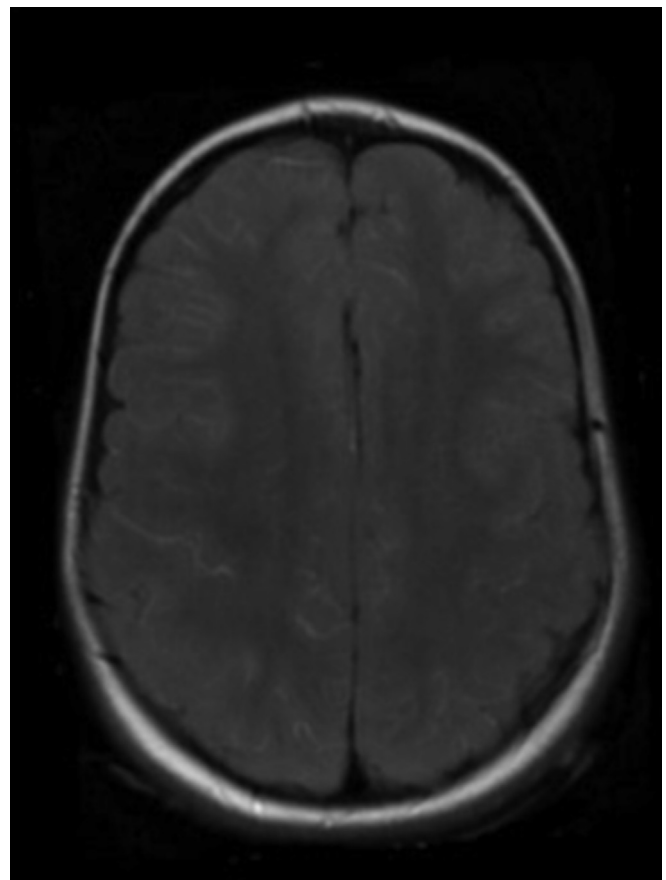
Axial T2/FLAIR image of a 16-year-old male patient with SCD, showing diffuse high signal of the cortical sulci (“ivy sign”), reflecting prominent pial vessels with slow flow, compensating for the steno-occluded proximal intracranial vessels.
